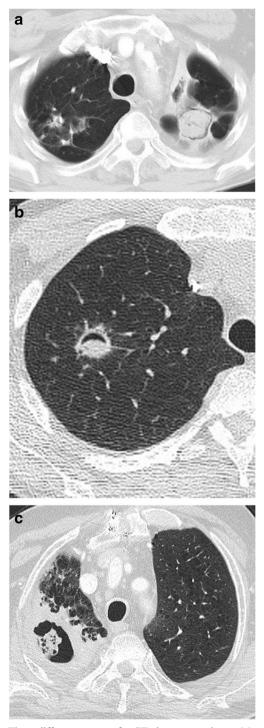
Three different causes of a CT air crescent sign. a Mycetoma: image through the upper lobes shows a fungal ball in a pre-existing fibrotic cavity (chronic sarcoidosis) at the left apex; b angioinvasive aspergillosis: targeted image of the right upper lobe in a severely neutropenic patient with a focal nodule (note that there is no evidence of pre-existing fibrocavitary disease) and c chronic pulmonary aspergillosis in a patient with chronic obstructive pulmonary disease and diabetes—the key features being adjacent consolidation and pleural thickening
